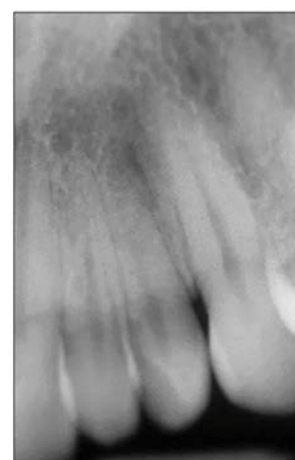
Periapical radiograph of maxillary lateral incisor #10 showing complete division.
